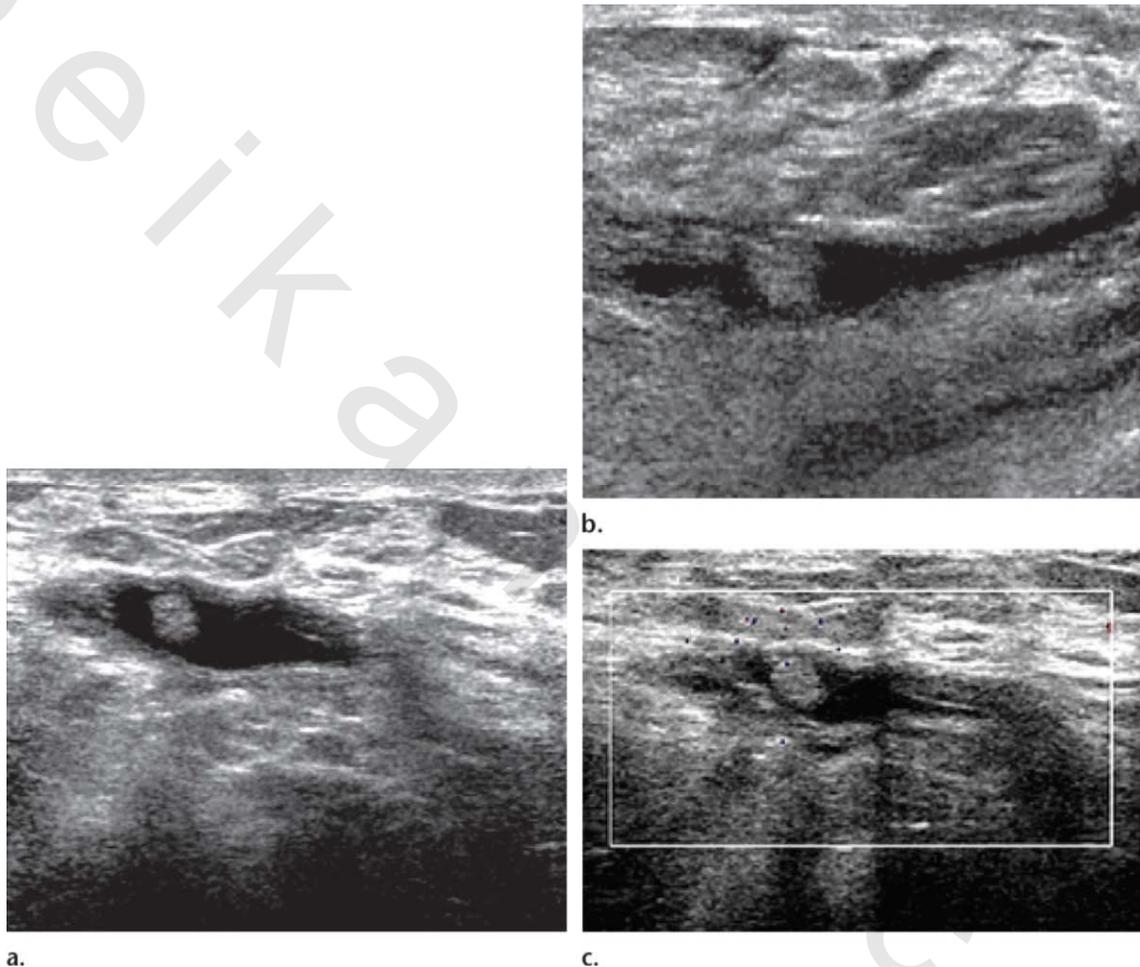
Postoperative seroma in a 66-year-old woman with a history of ductal carcinoma in situ (DCIS) and right breast lumpectomy. Radial (a) and antiradial (b) US images and color Doppler image (c) show an anechoic collection with an intracystic echogenic nodule that is nonvascular.
